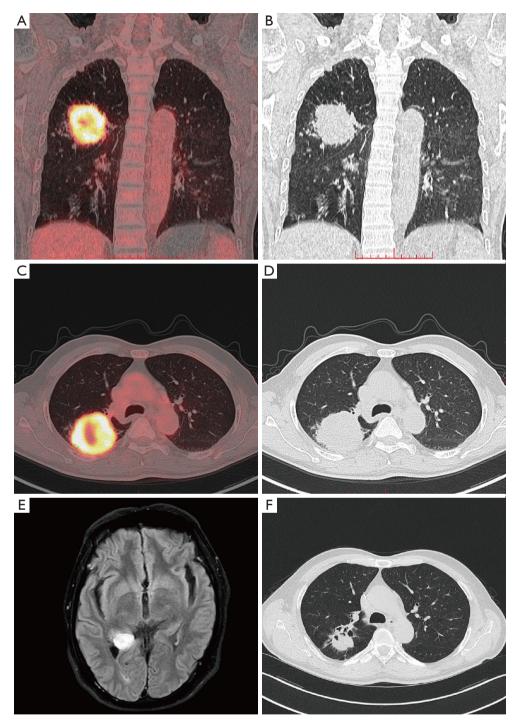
Lung and intracranial lesions in Patient ChiCTR-101. (A-D) Positron emission tomography/computed tomography imaging of pulmonary lesion upon diagnosis. (E) The intracranial lesion determined by fluid attenuated inversion recovery sequence of magnetic resonance imaging. (F) The decreased pulmonary lesion after two cycles of systemic therapy.
